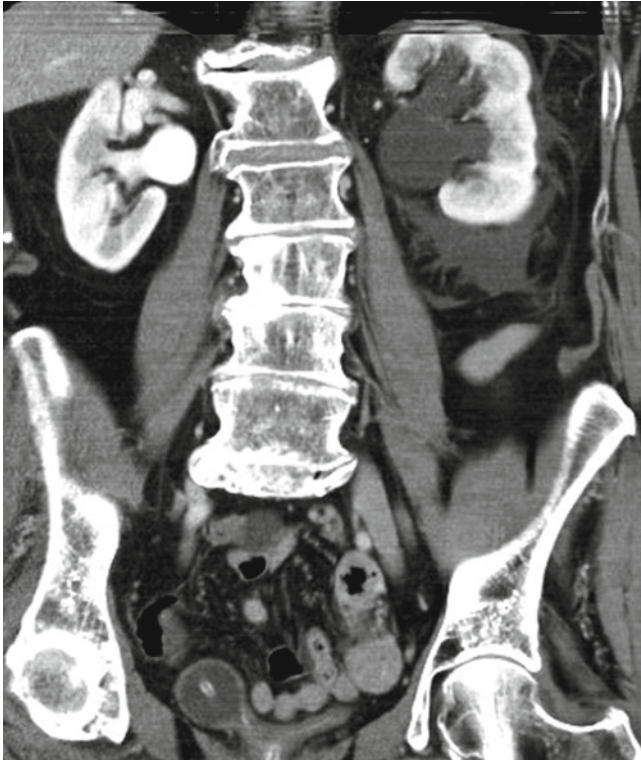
Delayed excretion of contrast in an 87-year-old female with left abdominal pain. Contrast-enhanced coronal CT image shows left hydronephrosis and delayed excretion of contrast (delayed enhancement) from the left kidney as compared to the right in this patient with an obstructing 9 mm left UPJ stone
